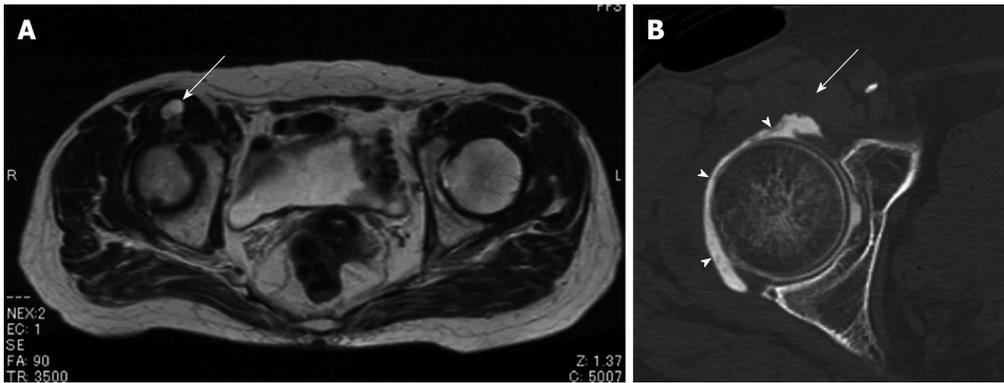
A 81-year-old female with femoral neuropathy caused by distended iliopsoas bursa. Axial T2-weighted magnetic resonance image shows a cystic lesion, which extends anteriorly into the iliopsoas muscle (A). Computed tomography arthrography demonstrates no communication between the cyst (arrow) and right hip joint (B). Arrowheads: Contrast material.
